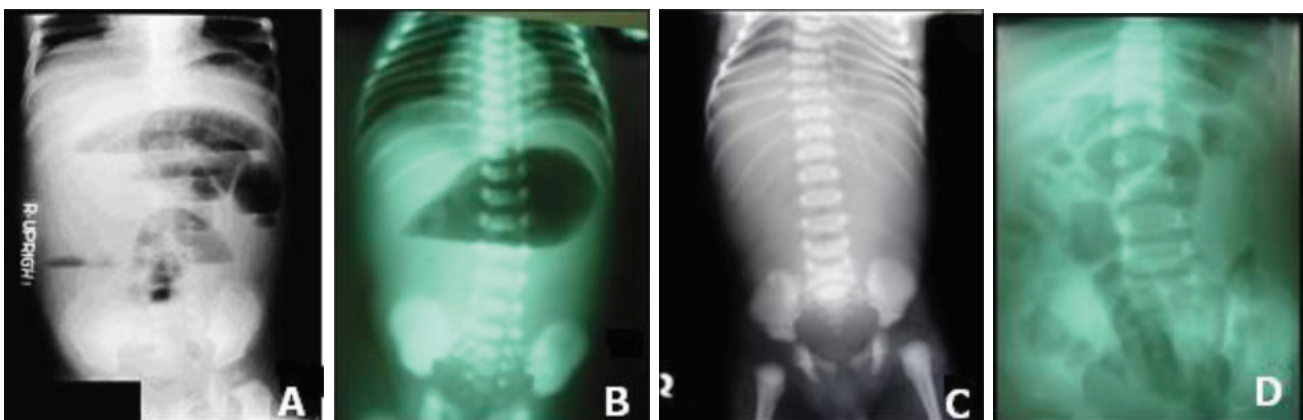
Plain films of abdomen in malrotation A. Complete small bowel obstruction B. High gut obstruction (only one gas bubble in the stomach) C. Gasless abdomen D. Normal finding
